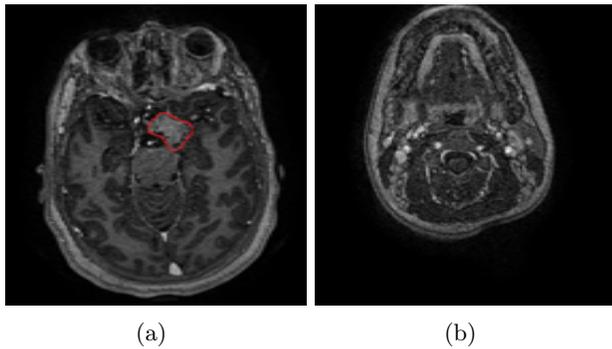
MRI image of (a) training dataset, and (b) test dataset
